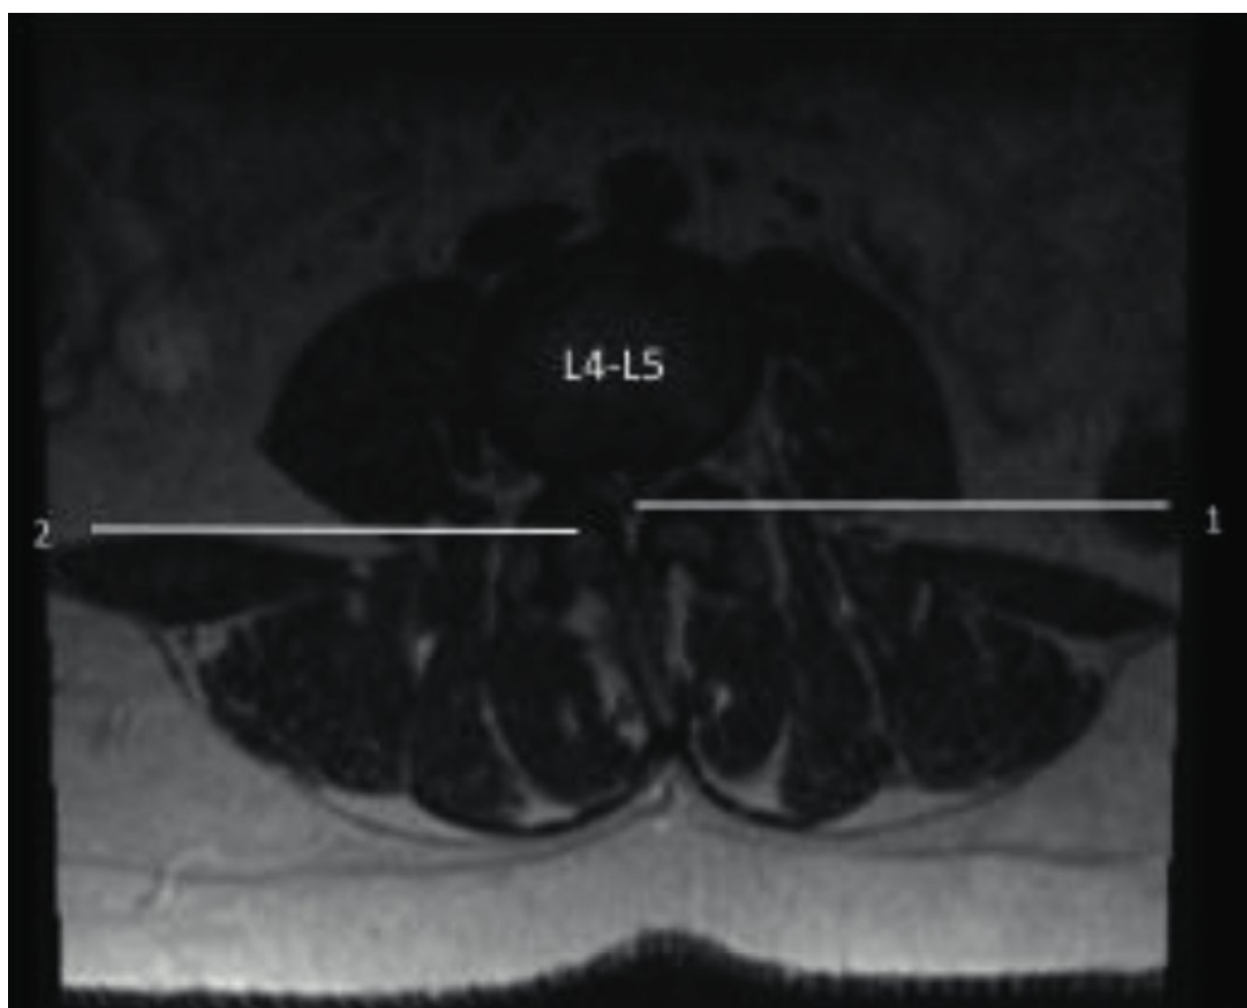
Magnetic resonance imaging axial cut at L4–L5 disk space. 1, severe lumbar spinal stenosis; 2, facet joint hypertrophy.
